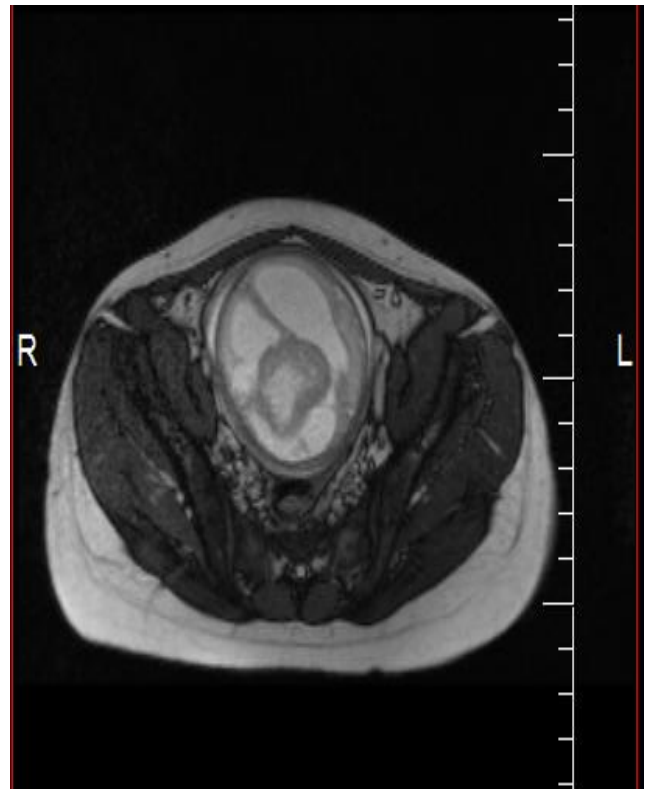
MRI of the fetal head
